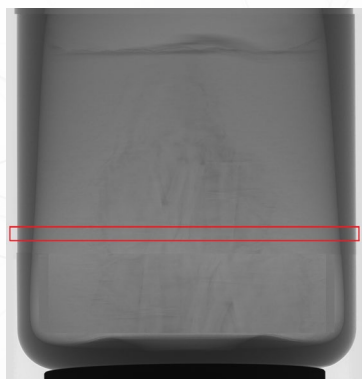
X-ray image of lyophilized mannitol in a 10mL plastic vial.
